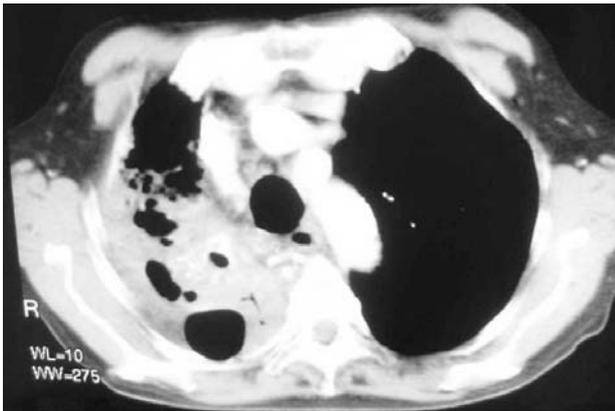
Thoracic computed tomography image showing a cavitated mass in the upper lobe of the right lung.
